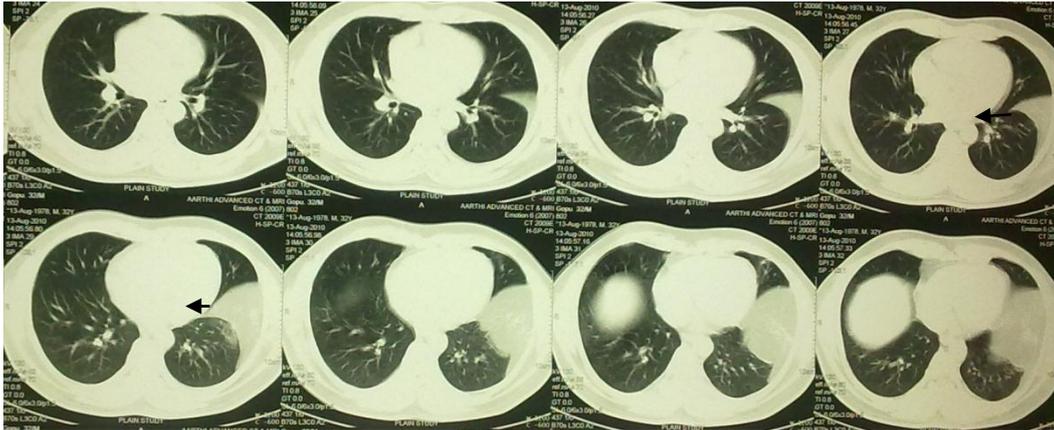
Computed Tomography Chest Lung window showing the diaphragmatic defect with the intestinal content (Black arrows).
